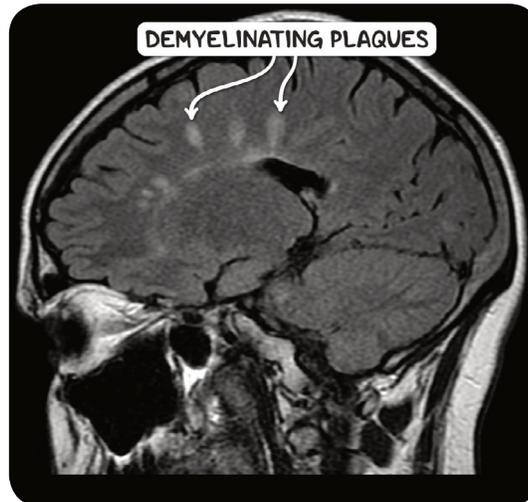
An MRI scan of the head in the sagittal plane demonstrating multiple demyelinating plaques adjacent to the corpus callosum. This radiological sign is known as Dawson's fingers and is specific for multiple sclerosis.
